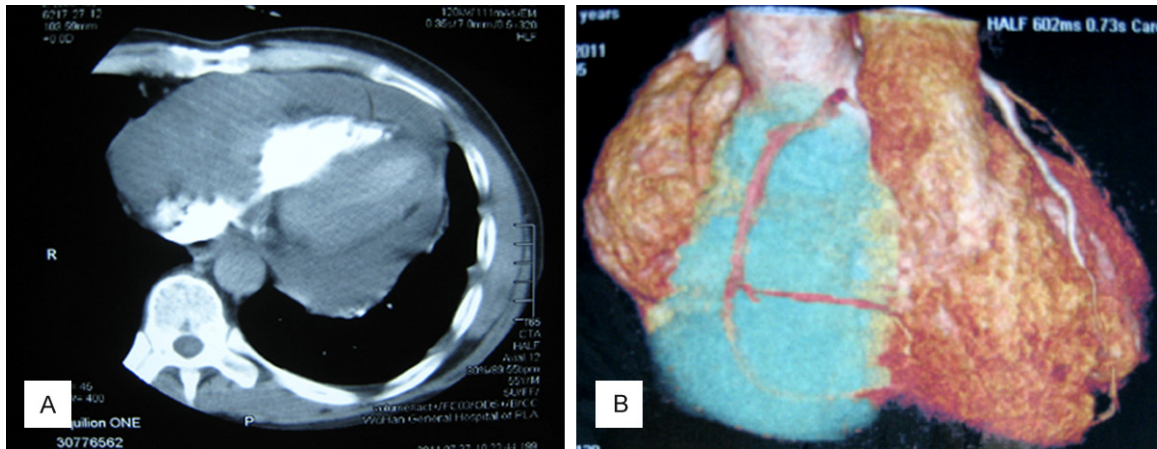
Computed tomography (CT) imaging of the heart before the surgery showing a mass in the cardiac space occupying approximately 7.3 cm × 5.9 cm × 6.2 cm. A: Tumor in the right atrium and hydropericardium (+), B: 3-D reconstruction for the CT images, the tumor is in blue.
